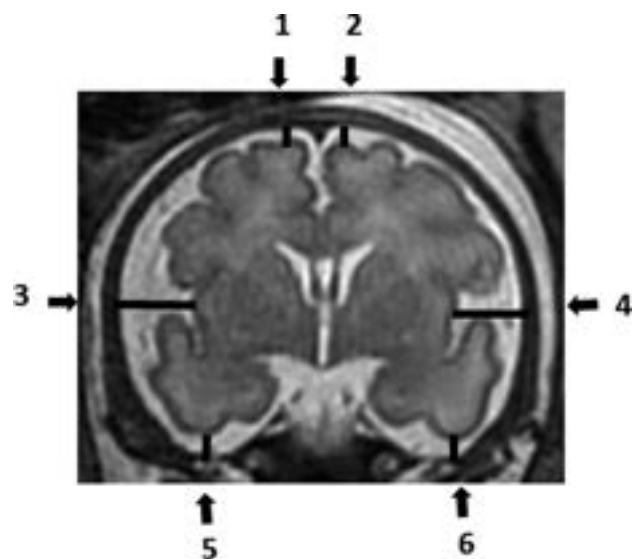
Coronal T2-weighted fetal brain image demonstrating the measurements of the subarachnoid space: 1) Right frontal gyrus. 2) Left frontal gyrus. 3) Right insula gyrus. 4) Left insula gyrus. 5) Right inferior temporal gyrus. 6) Left inferior temporal gyrus.
